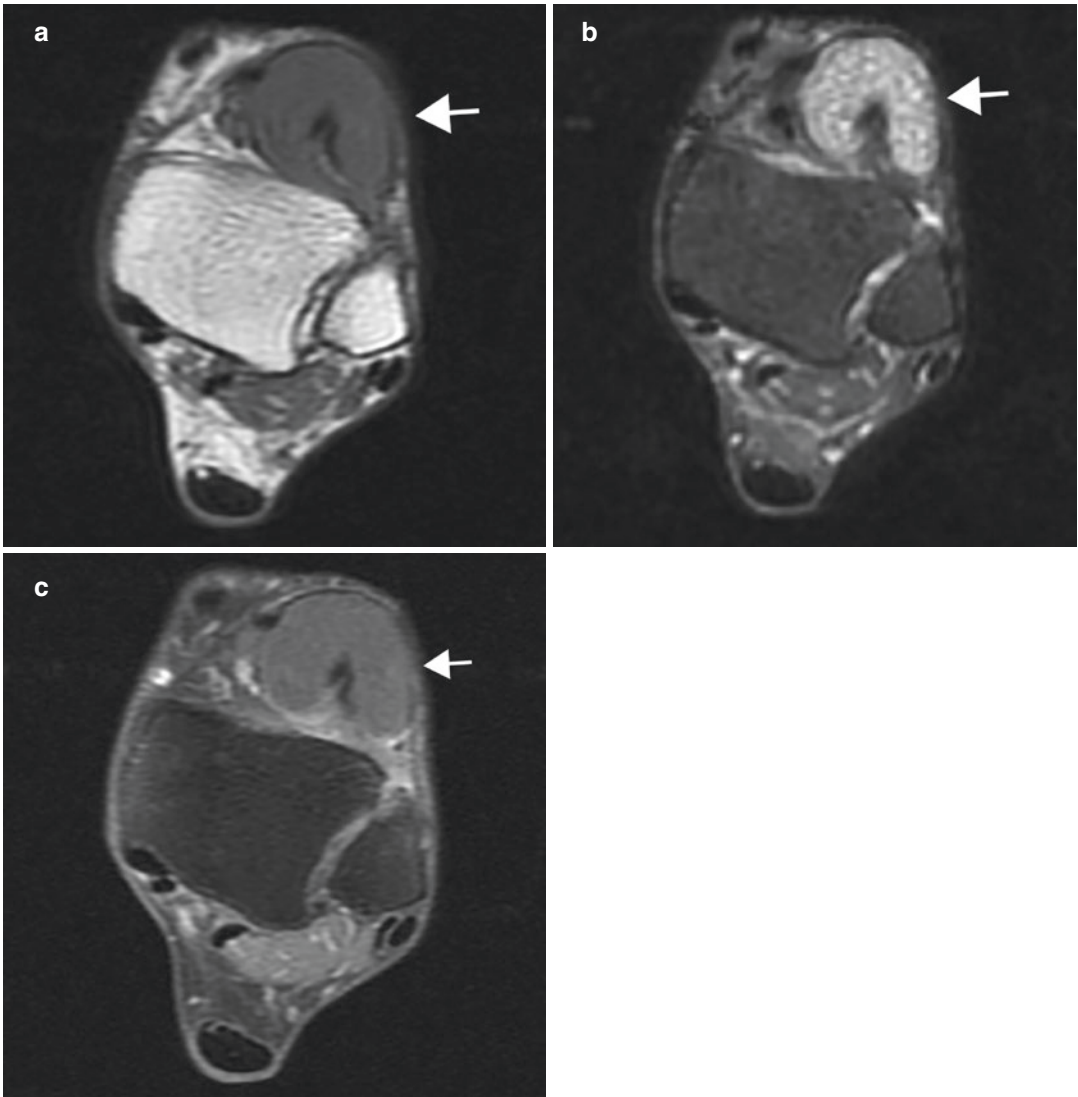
Tuberculous tenosynovitis with rice bodies in a 70-year-old woman who had a soft tissue mass at the ankle for 1 year. Axial (a) T1-weighted, (b) T2-weighted, and (c) contrast-enhanced fat-suppressed T1-weighted
